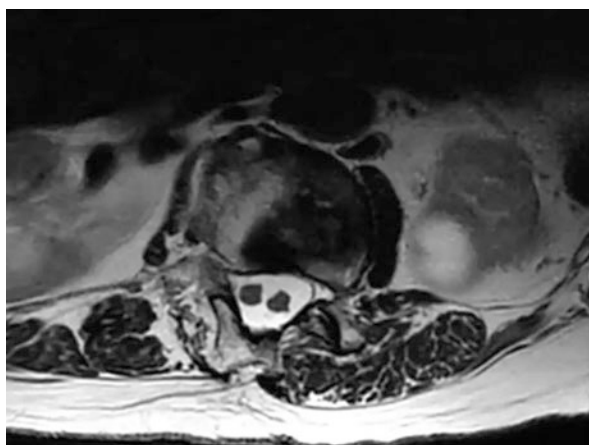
(a) T2 axial MRI at level of L1 showing owl sign of type I SCM with two hemicords contained within two separated thecal sacs. (b) Axial CT scan bone window at L1 lumbar vertebra showing bony septum that separate completely the spinal canal with bifid spinous process
